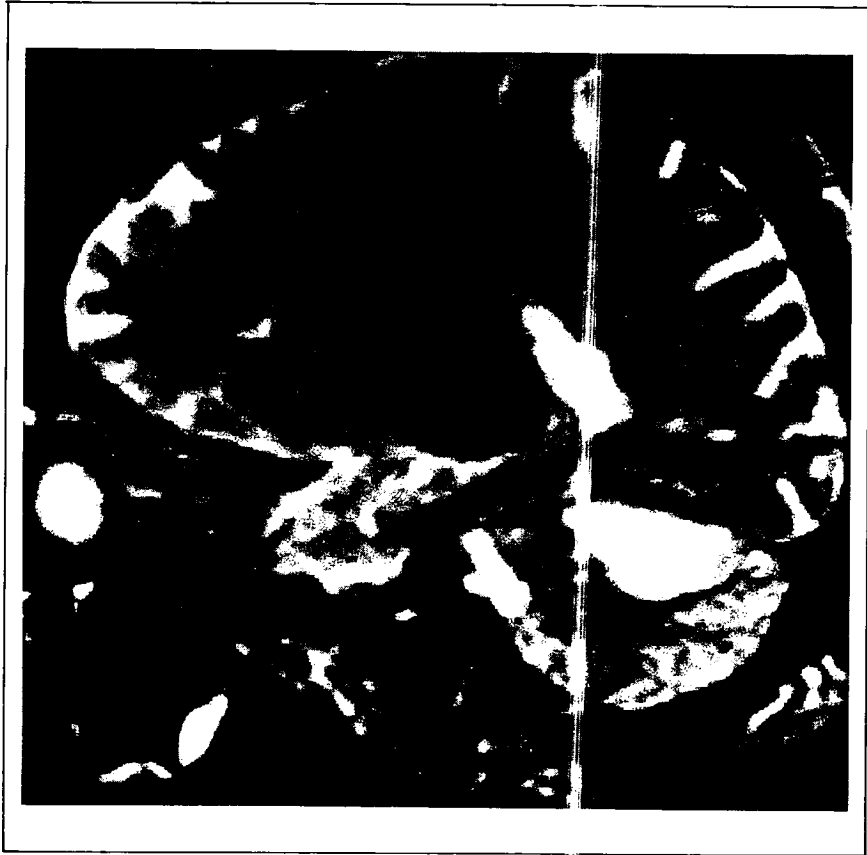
MRI T2 - weighted sagittal section to the left of midline. On this section cerebellar infarction is above the sulcus and in the superior cerebellar artery territory.
